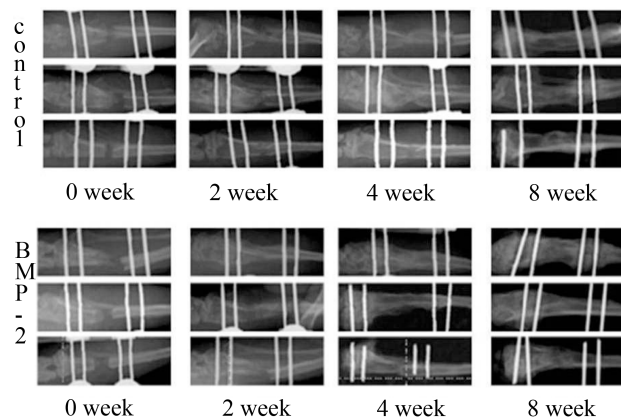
Representative 2D radiographs of both control and treated (BMP-2 injected) tibia at 2, 4, and 8 weeks after surgery.
